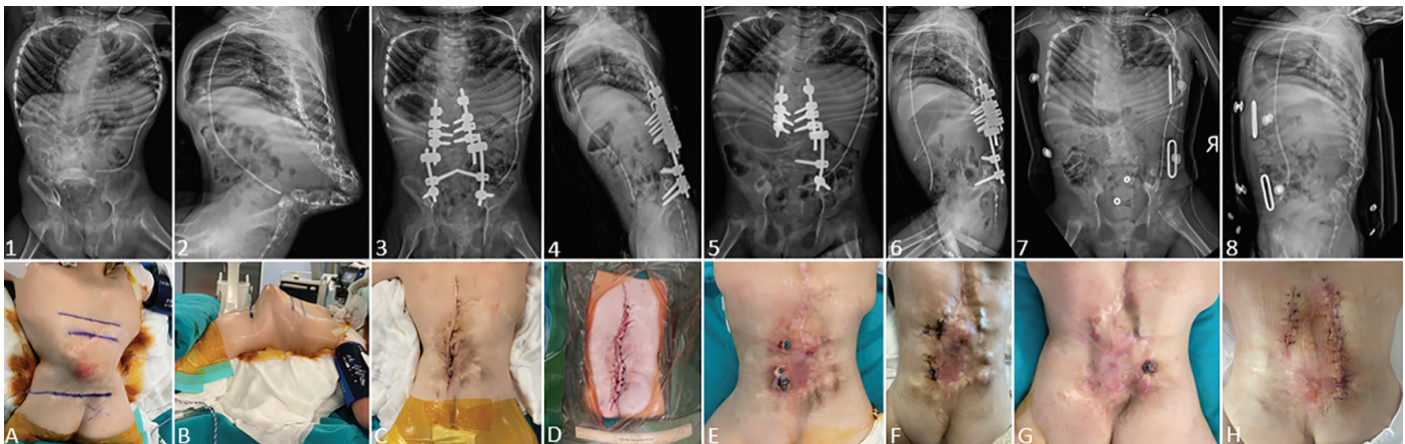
(1) and (2) show X-ray images of a patient with myelomeningocele taken before deformity surgery. (3) and (4) show X-ray images taken after the first surgical debridement. (5) and (6) show the results of the second surgical debridement, which involved implant removal due to exposure. (7) and (8) show the X-rays taken after the third surgical debridement, when all the implants were removed due to exposure. (A) and (B) show photographs of the patient's skin before the initial deformity surgery. (C) and (D) are photographs of the patient's skin before (C) and after (D) the first surgical debridement at 3 weeks after index surgery. (E) and (F) are photographs of the patient's skin before (E) and after (F) the second surgical debridement at 4 months after index surgery. (G) and (H) are photographs of the patient's skin before (G) and after (H) third surgical debridement at 6 months after index surgery
